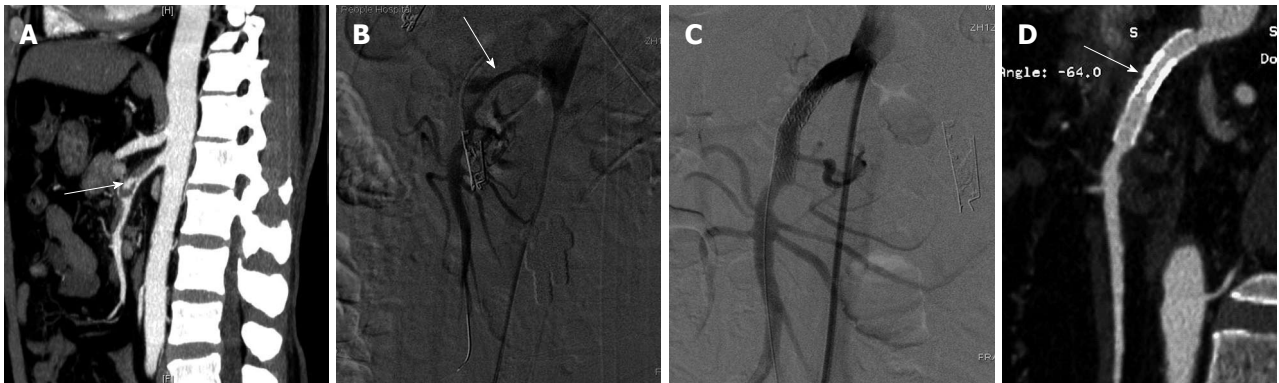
Two overlapping stent-in-stent technique. A: Computed tomography angiography (CTA) showing a thrombus generated inside the false lumen, an ulcer-like niche intruding into the false lumen (indicated by the arrow); B: DSA demonstrating isolated superior mesenteric artery dissection (ISMAD) and narrowing of native lumen (arrow); C: Post two bare stent (a balloon-expandable and a self-expandable bare) deployment, repeat angiograph showing complete exclusion of the true lumen preserving patency of the superior mesenteric artery; D: Follow-up CTA at 5 mo, demonstrating disappearance of the false lumen and patency of true lumen (arrow).
